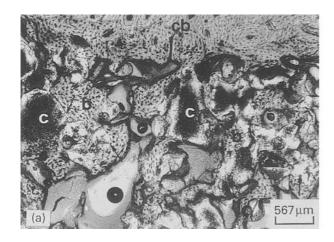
(a) Overview, at 12 weeks, in BSE of the 5-mm defect showing extensive bone (b) ingrowth. c = cortex. (b) Detail from Fig. 4a (large arrow in (b) corresponds with the arrow in (a)). Bone (b) has infiltrated from the cortex (cb). Note the extensive calcification (c) of the implant and the high contact (small arrows) rate between bone and calcified material. (c) X-ray mapping for calcium of the area shown in Fig. 4b (× correspond in (b), (c) and (d)). X-ray mapping for phosphorus The X-ray mapping in (c) and (d) confirmed the morphological continuum in calcium and phosphorus signal at the bone/calcified implant interface. (e) LM-morphology of the bone (b)/implant (I) interface. Arrows point to continuity at the interface with calcified material (c).
